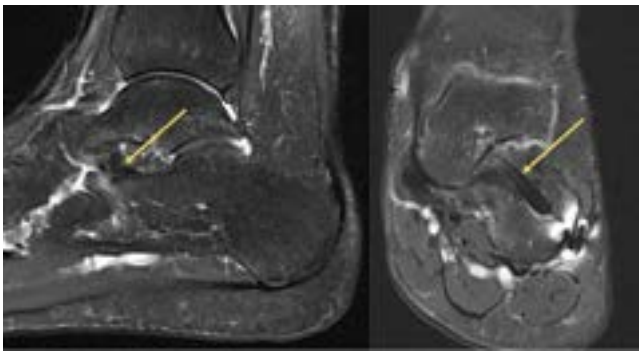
Follow up MRI at 6 months from surgery showing intact graft.
